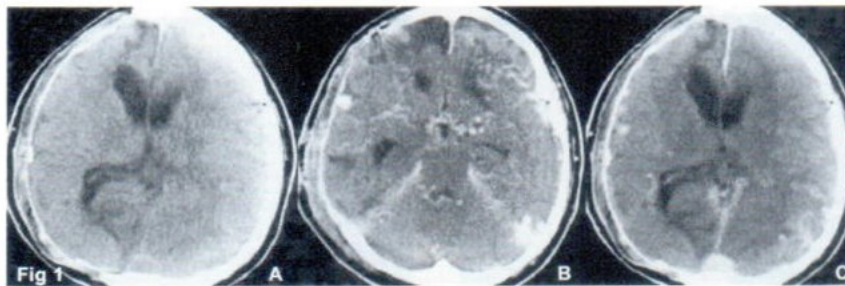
A-C Cranial CT scan showed abnormal vascular structure at skull base and dilated Rt. superior ophthalmic vein, Rt.superficial middle cerebral vein and prominent Rt.cavernous sinus without Intracranial hemorrhage (ICH).
